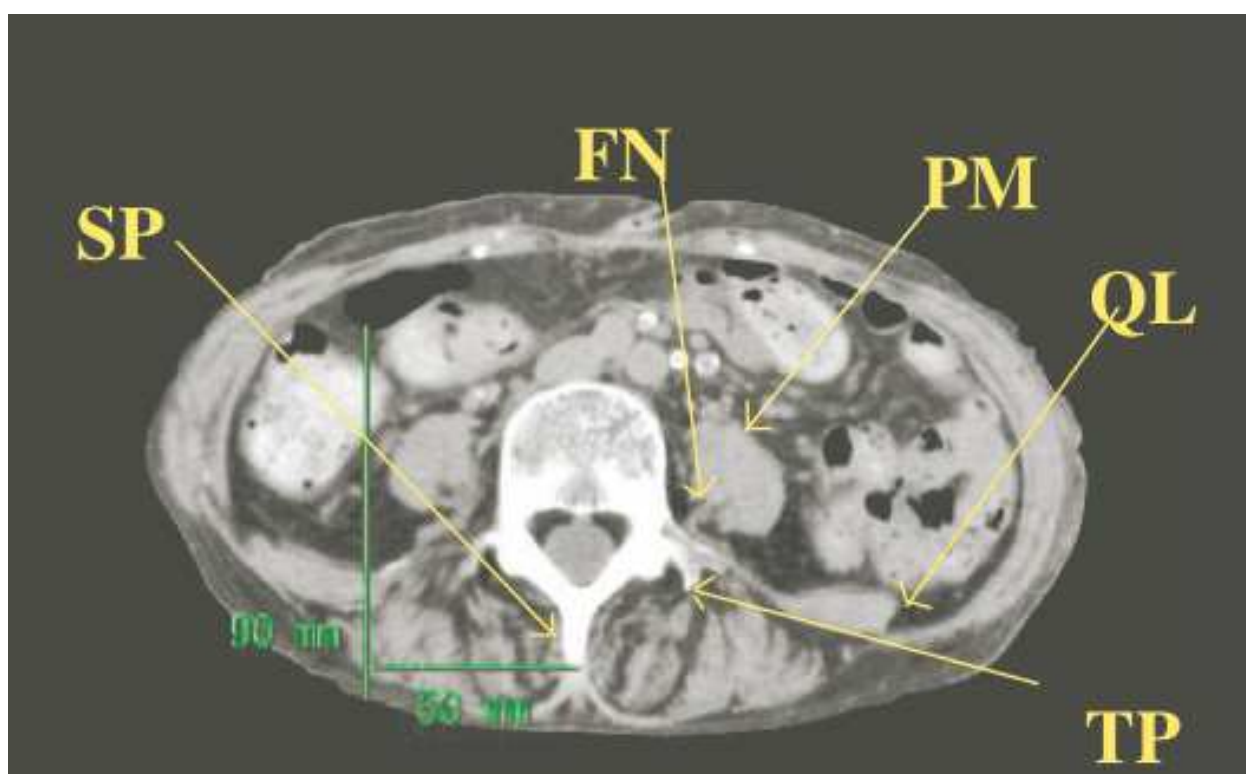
Localization of the spinous process (SP), transverse process (TP), femoral nerve (FN), psoas major muscle (PM), and quadratus lumborum muscle (QL) on the computed tomography at the 4th lumbar spine level is shown.
